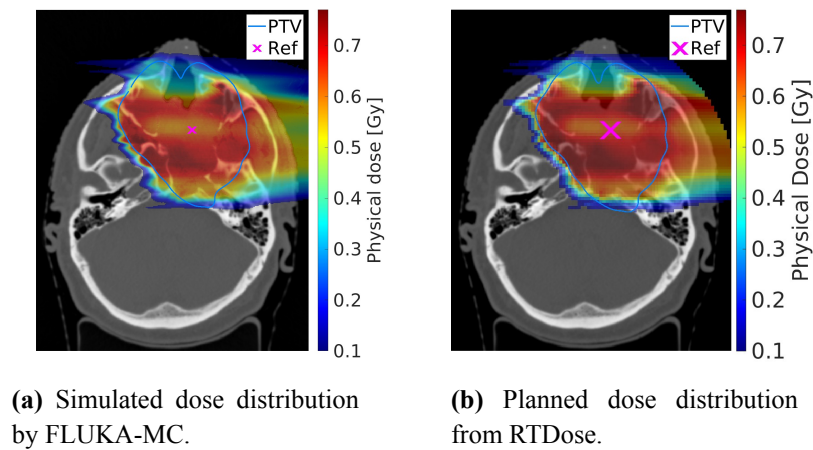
Dose distribution of the 5° beam corresponds to one treatment fraction on top of an axial CT slice at the isocenter. The blue contour outlines the PTV, and the magenta cross marks the projection of the isocenter perpendicular to the axial plane.
